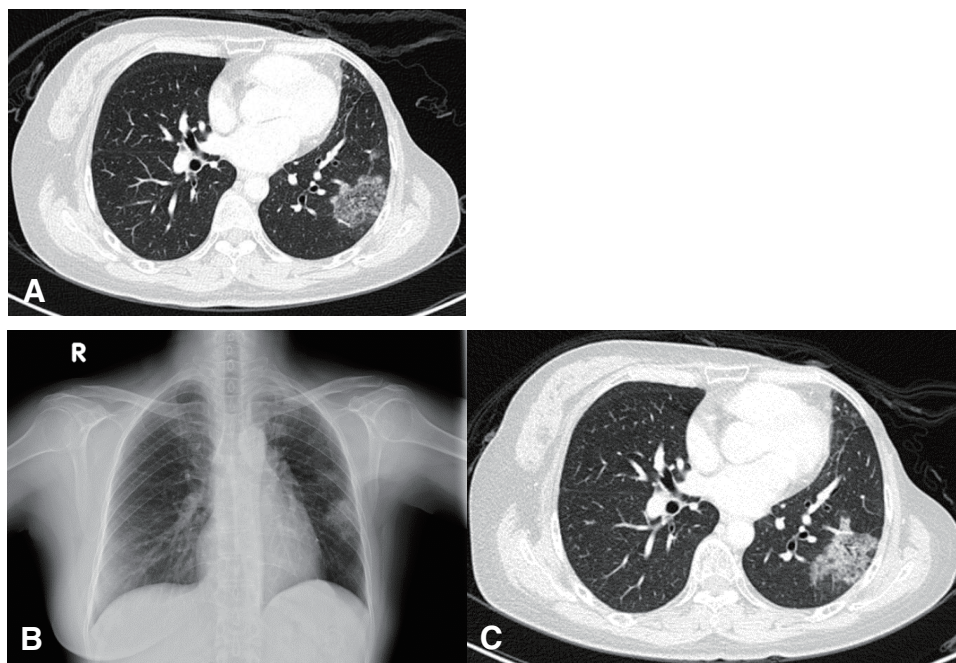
Image modality survey. (A) CT scan disclosed GGO in the left lower lung 1 year before surgery. (B) Chest roentgenograms revealed infiltration in the left lung field. (C) CT scan disclosed progression in the size of GGO in the left lower lung. CT: computed tomography; GGO: ground-glass opacity
